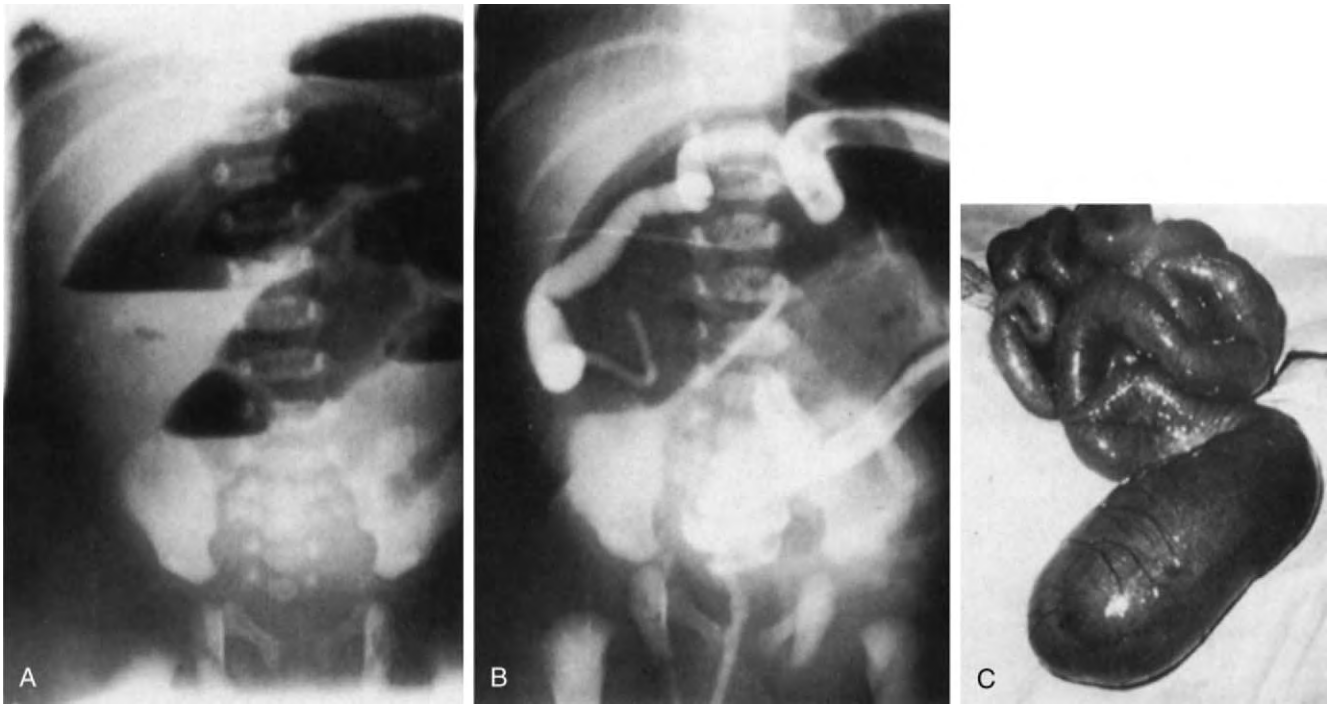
Ileal atresia. A, Erect abdominal radiograph showing distended intestinal loops with air-fluid levels. B, Contrast enema demonstrating a microcolon (unused), suggestive of small bowel obstruction. C, Atresia of the ileum (type IIIa) at laparotomy. (From O'Neill JA Jr, Rowe MI, Grosfeld IL, et al [eds]: *Pediatric Surgery*. St Louis, Mosby-Year Book, 1998.)
